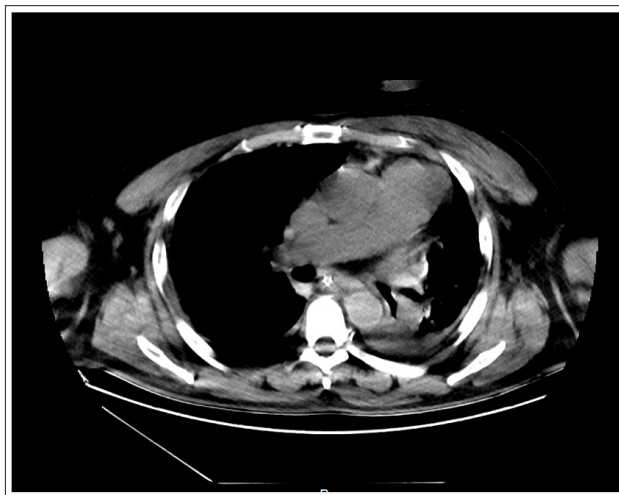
Mediastinal CT on May 10 showed that the pulmonary artery was wider than that on May 9
